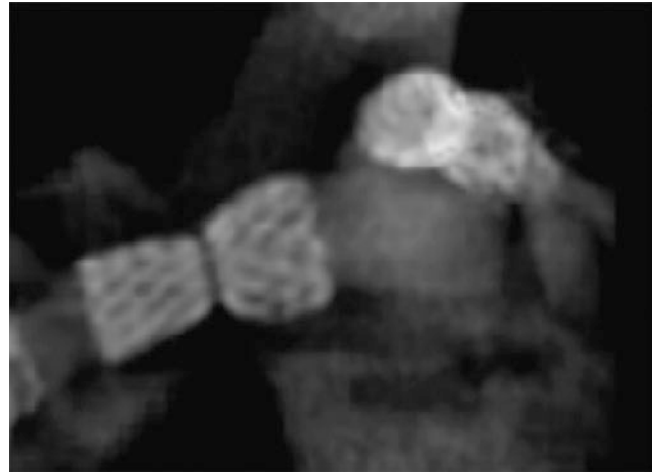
Bilateral pulmonary artery stenting for branch pulmonary artery stenosis in a 4-year-old, contrast-enhanced CT. Coronal image viewed from the front of a right pulmonary artery fractured stent with pulmonary artery restenosis. The left pulmonary artery stent is seen end on and is seen to be narrowed
